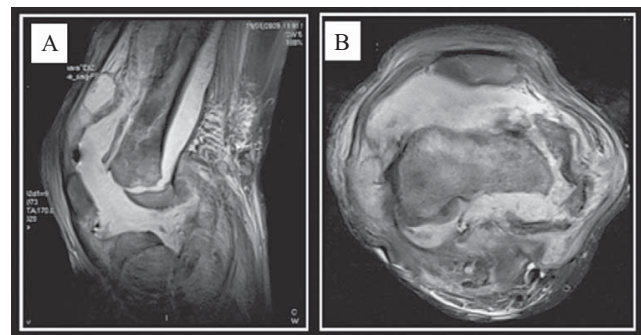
(A) Epiphysis appeared to be displaced. Moreover tibia appeared to be displaced laterally on the sagittal T2-weighted image. (B) Massive effusion appearing within the muscles and within the knee joint, increased intensity of the muscles on wide-spread loss in the cortex in the bones, especially more prominent in the tibia were determined on the axial T2-weighted image.
